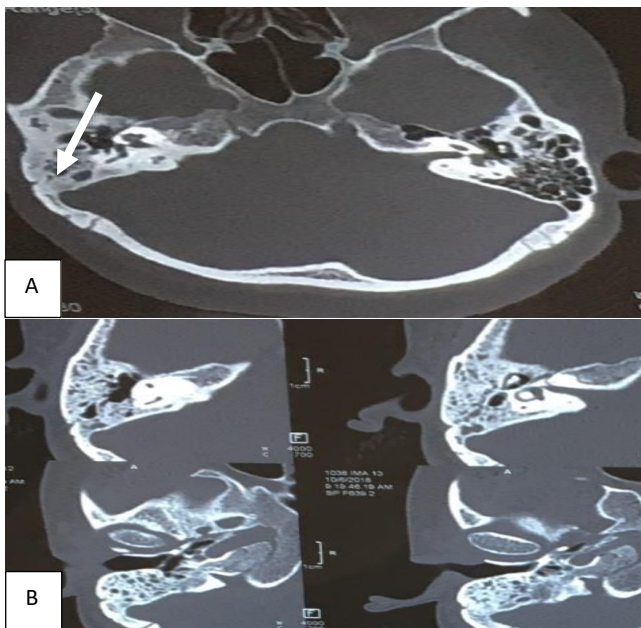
(A and B): An axial HRCT temporal bone with right COM showing right mastoid cavity opacification as compared to left normal mastoid cavity. (Arrow pointing to opacified mastoid cavity).
